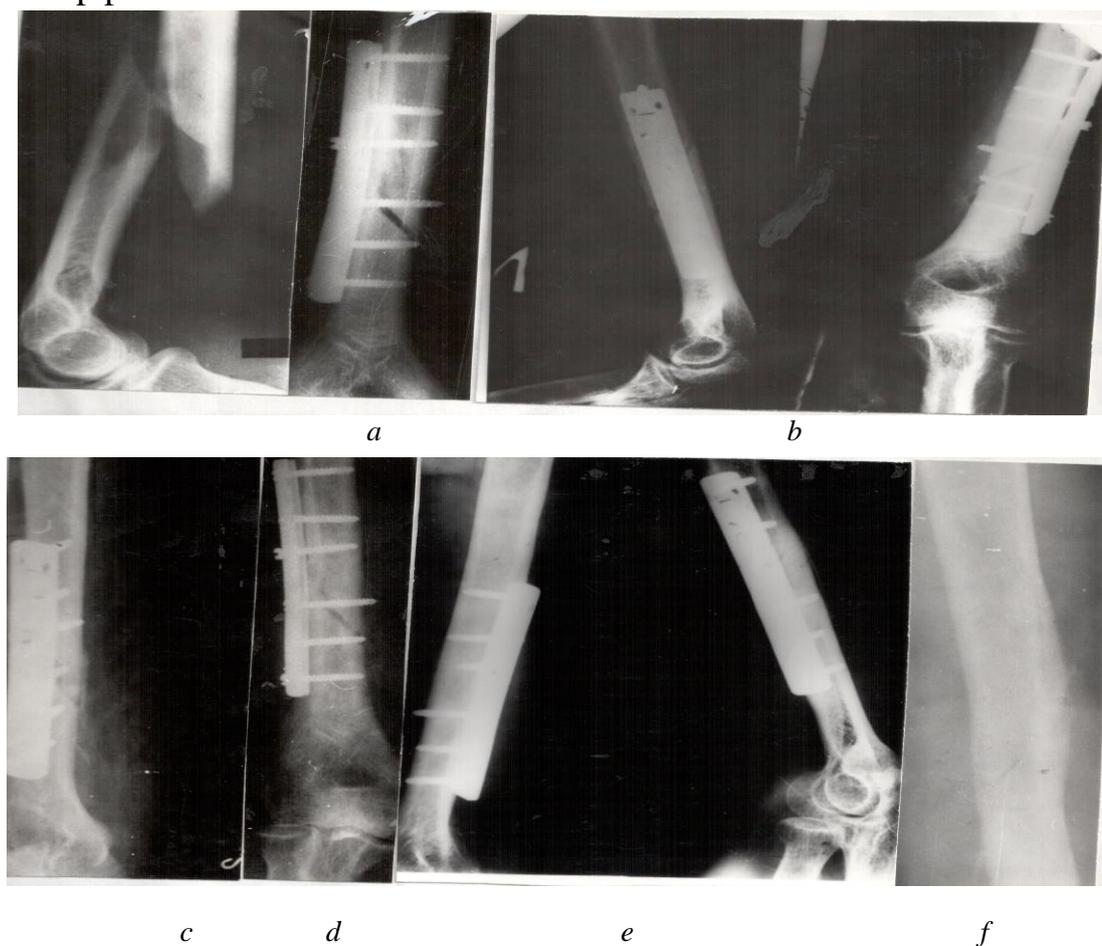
Radiography images of patient G. MN. Left shoulder fracture in the midleg (a). Fragments are fixed by plate with screws "METOST" (115 x 6), Day 3 after operation (b). Follow-up period
